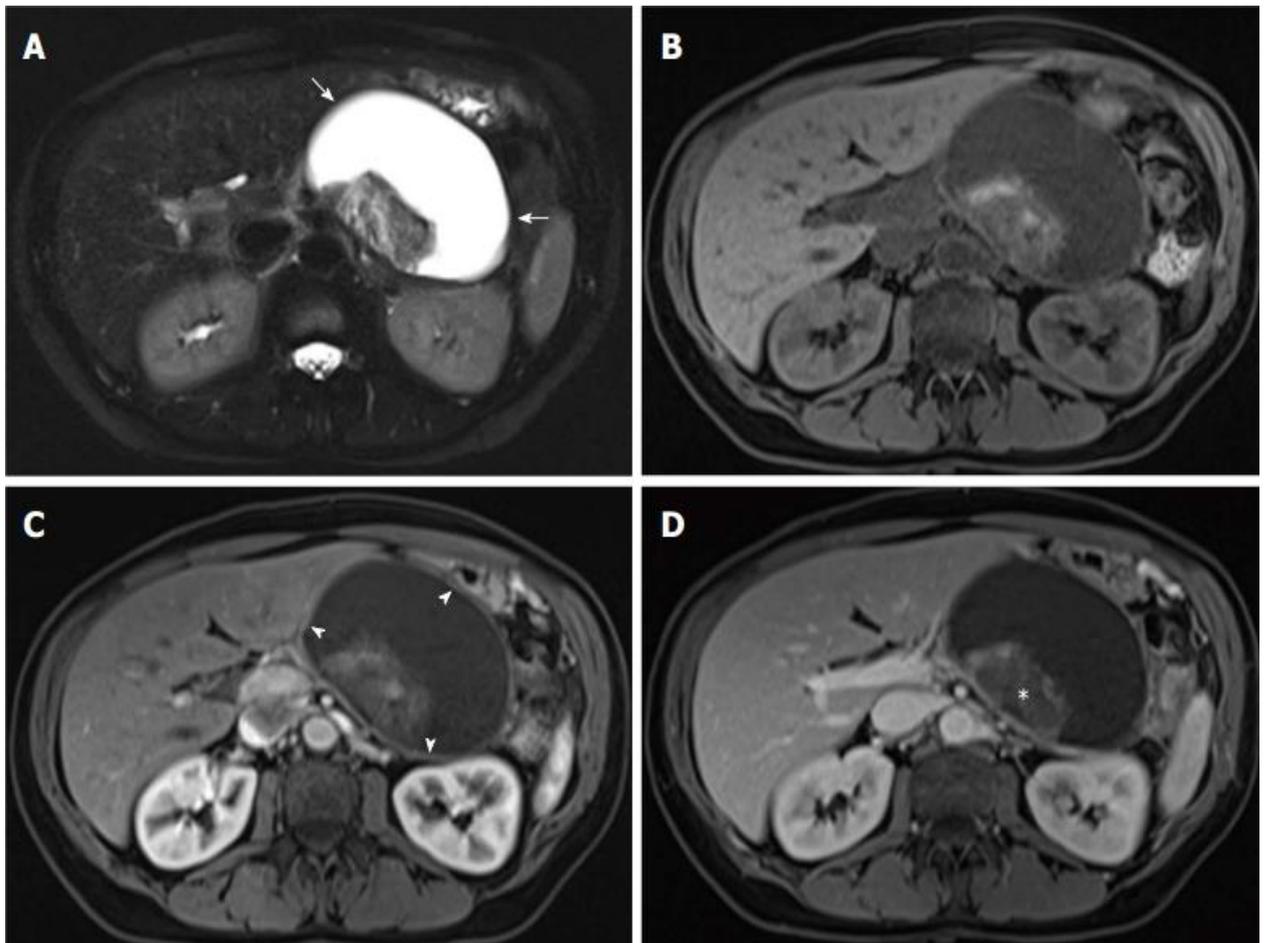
A 45-year-old patient with delimited necrosis. On the turbo spin echo T2-weighted image (A) and on T2-weighted images before contrasting (B), in the arterial (C) and venous phases after contrasting, a large-scale liquid formation with formed walls is detected, containing solid inclusions (sequesters)
